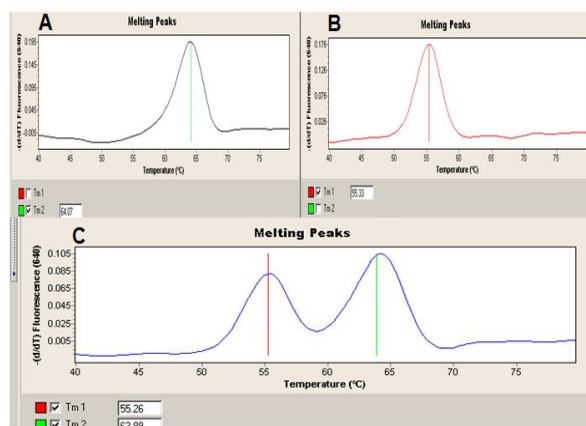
Shows Melting Peak Profiles of Real Time – PCR for wild (A) and Mutated Genotypes for *MDR1* 3435 C>T SNPs in the Current DTC Patients. B: Homozygous Mutated TT Alleles, C: Heterozygous CT alleles
